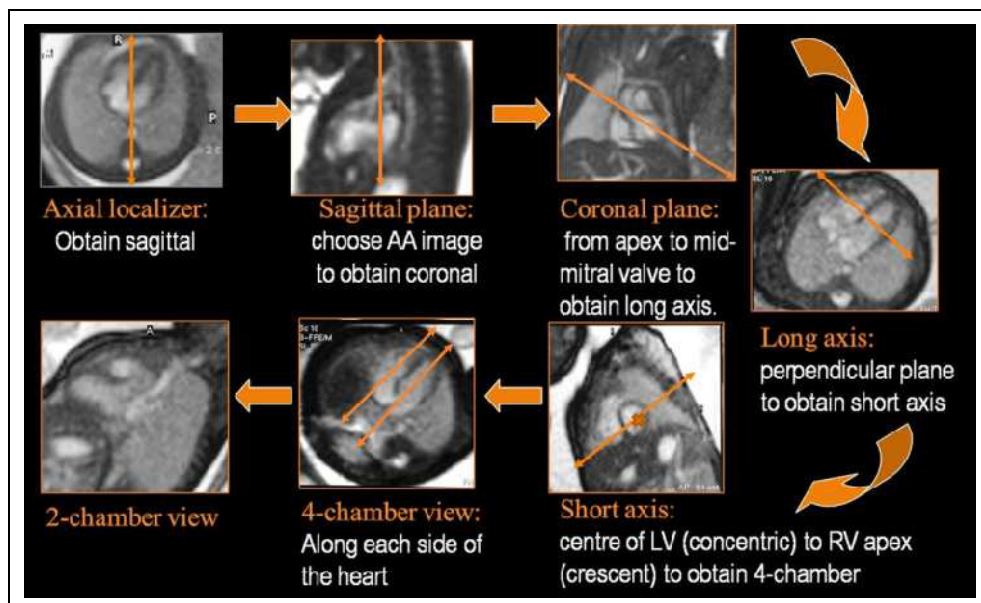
MR imaging of fetal heart along three fetal body planes as well as cardiac axes.
